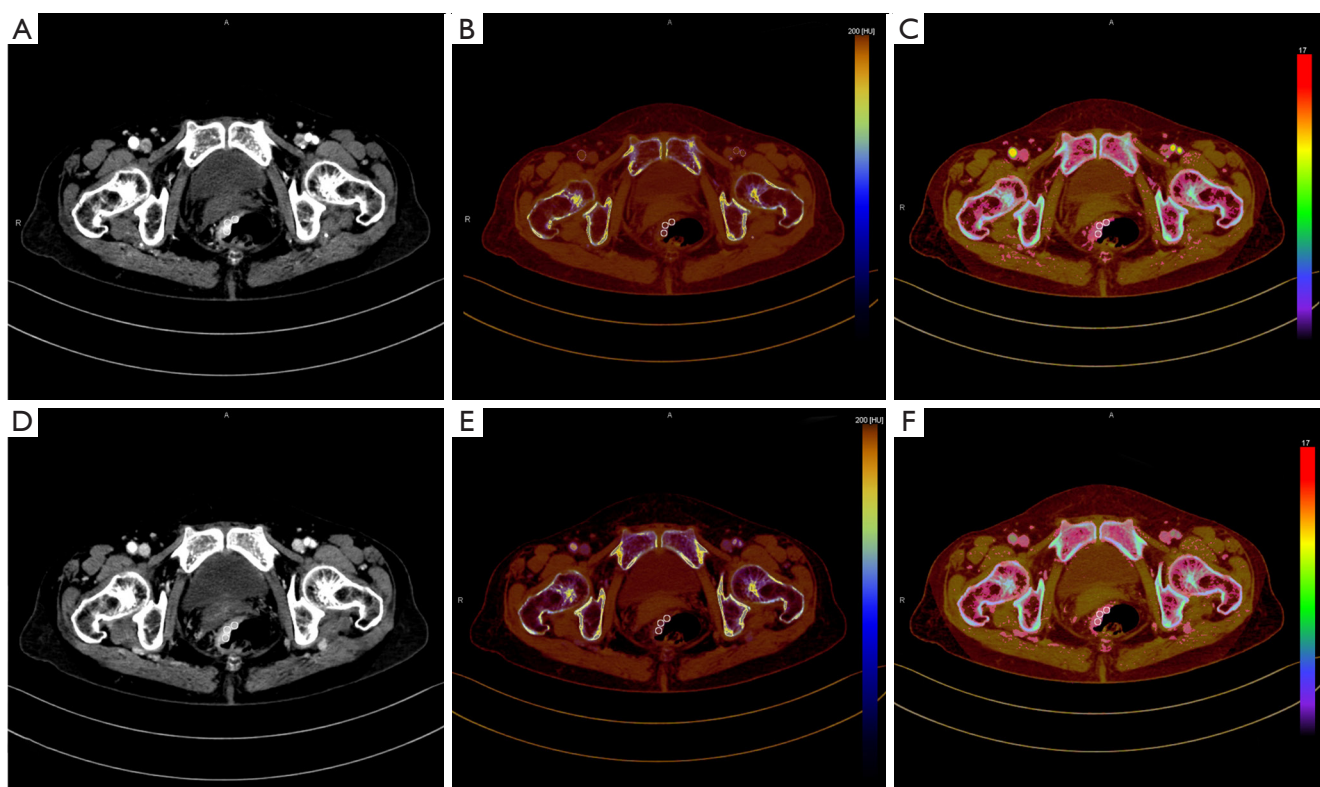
An 80-year-old woman with rectal cancer pathologically confirmed as a moderately highly differentiated adenocarcinoma without metastasis. (A) Images with an optimal SNR and CNR at 40 keV VMI+ in the arterial phase; (B) DECT images of IC in the arterial phase; (C) images of the effective atomic number and electron density in the arterial phase; (D) images of 40 keV VMI+ in the venous phase; (E) DECT images of IC in the venous phase; (F) images of the effective atomic number and electron density in the venous phase. SNR, signal-to-noise; CNR, contrast-to-noise ratio; VMI+, virtual monoenergetic imaging based on Mono+ algorithm; DECT, dual-energy computed tomography; IC, iodine concentration.
